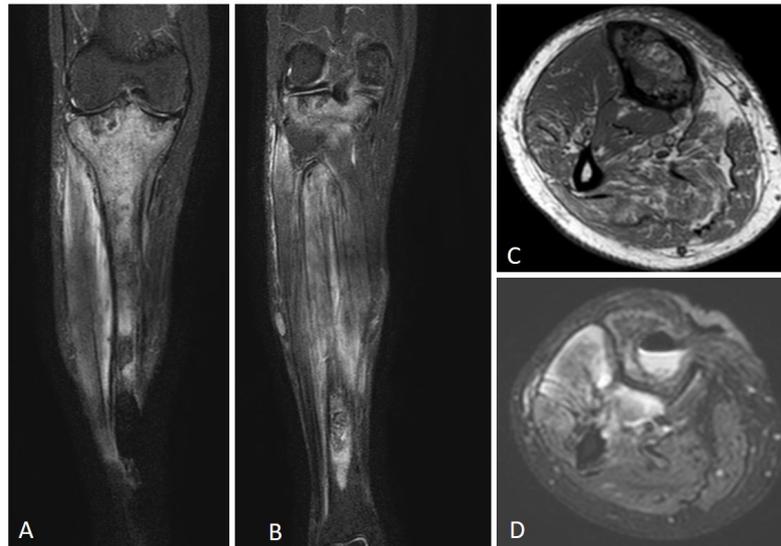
MRI images. (A and B) Fat suppressed T2 coronal images showing extensive marrow signal alteration involving the tibia. (C) Axial T1 weighted image showing cortical irregularity and erosions of the tibia. The fibula (*) shows normal marrow and cortical signal. (D) Axial fat suppressed T2 weighted image shows an air fluid level within the tibial marrow cavity with sinus tract extending to the skin surface (*). Note also the extensive edema involving the surrounding muscles (arrow).
